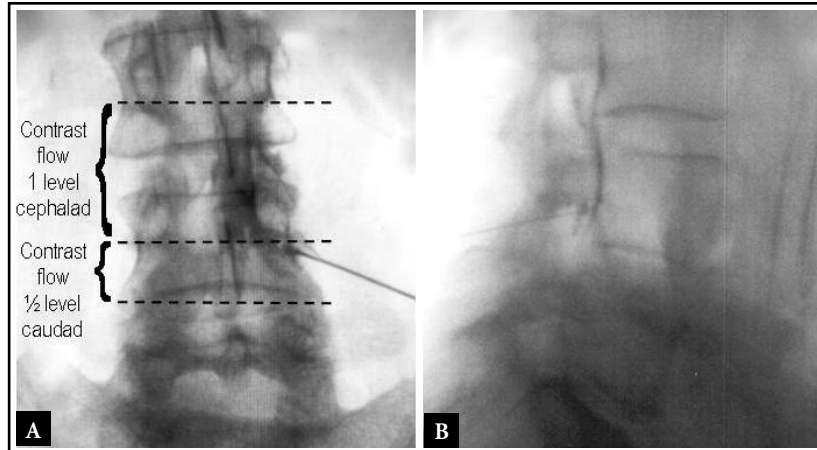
AP radiograph (left) of transforaminal injection at L4-5 intervertebral level. Note contrast appears to flow cephalad 1 level to the superior pedicle, does not cross the midline. Lateral radiograph (right) shows ventral flow of contrast cephalad 1 level to the superior pedicle from injection site
